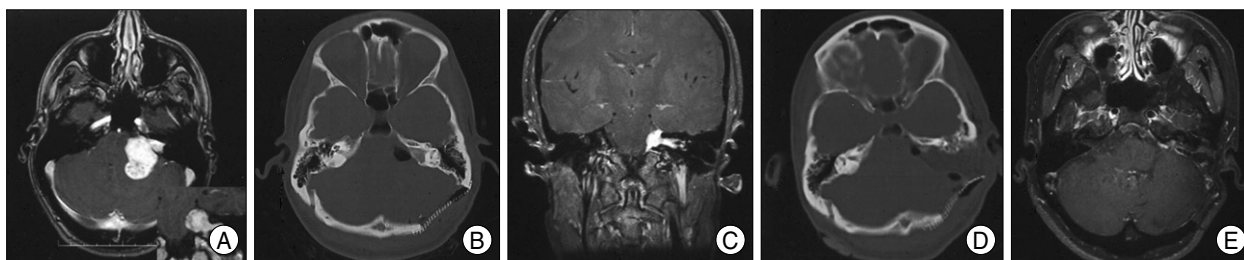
A patient with large vestibular schwannoma who underwent a staged retrosigmoid-translabyrinthine approaches with one month interval between operations. An enhanced magnetic resonance (MR) image reveals a tumor deeply embedded into the brain stem and cerebellum. The lateral portion of tumor is also prominent (inset) (A). The bony defect of the left occipital region is noted on computed tomography (CT) scan after stage-one procedure. The internal auditory meatus is widened, but not drilled (B). The coronal MRI before stage-two resection shows a lateral remnant of the tumor (C). The bone window CT reveals resection of the mastoid and bony labyrinth through the second stage approach (D). The MR obtained at one year after the surgery demonstrates no evidence of residual tumor (E).
